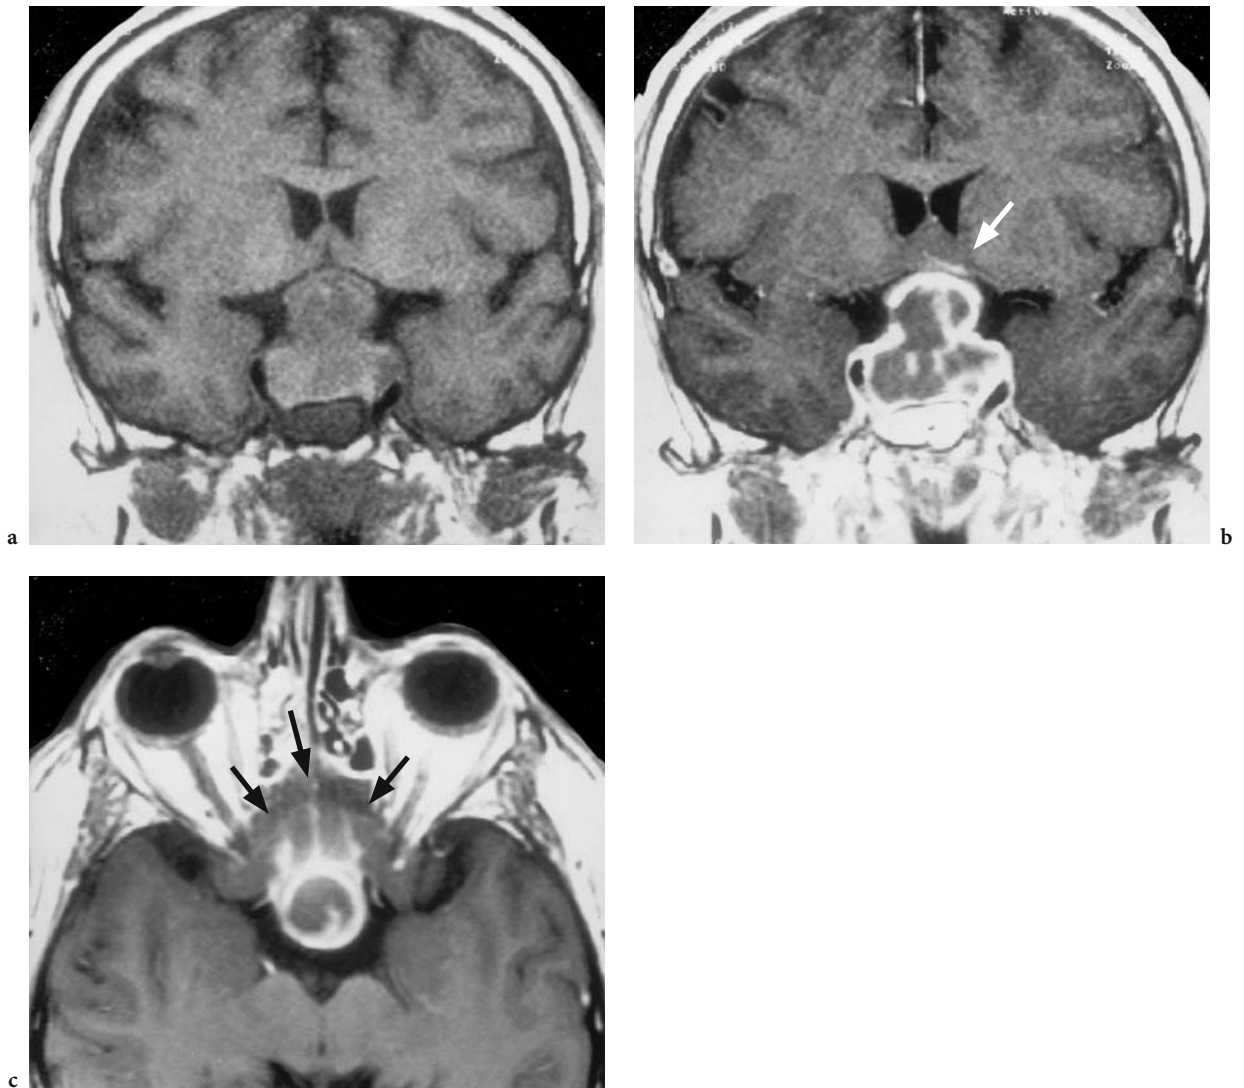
A 47-year-old man who presented in pituitary coma. After substitution, he complained of headache and variable visual deficits. Hemianopia to the left, visual deficit (right: 0.6, left: 0.2) was found, together with an inflammatory clinical constellation with fever and meningism. Diagnosis: abscess-forming pituitary adenoma with adjacent bacterial leptomeningitis. T1-weighted MRI: a Coronal native view with intra- and suprasellar lesion and inferior chiasmal compression. Note the slightly hypointense signal in the sphenoid sinus. b Corresponding contrast-enhanced view with inhomogeneous contrast enhancement of the intra-/suprasellar, apparently encapsulated lesion, but homogeneous enhancement in the sphenoid sinus. CORR = Sponting to sinus inflammation, note the small leptomenigeal enhancement at the base of the left frontal lobe (*arrow*). c Axial contrast-enhanced view with necrotizing, encapsulated tumor and leptomenigeal enhancement of the basal frontal sulci (*arrows*)
